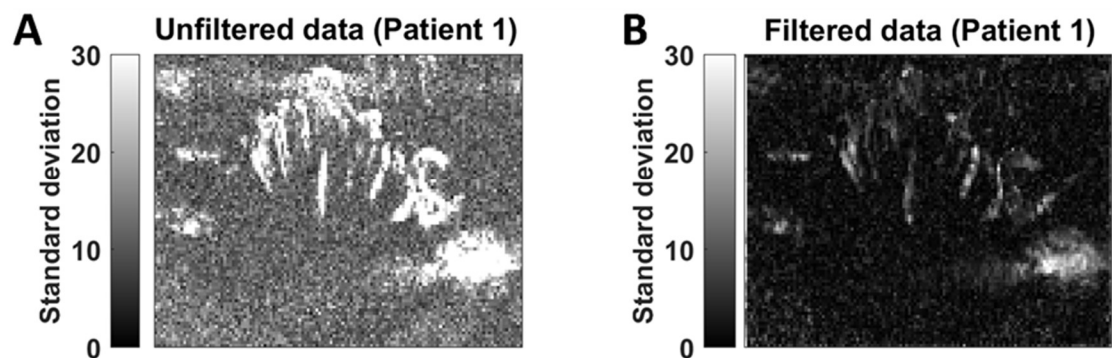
S.2 Variance of pD signal during baseline periods (i.e., 6 seconds prior to stimulation onset) in pre- and post-motion correction. A) Pixelwise standard deviation in unfiltered fUSI pD intensity signal during baseline periods (patient 1) B) Pixelwise standard deviation in filtered fUSI pD intensity signal during baseline periods (patient 1). Motion correction algorithms reduce the standard deviation of the power Doppler intensity signal during baseline, indicating that most of the motion artifacts are significantly removed from the fUSI image.
